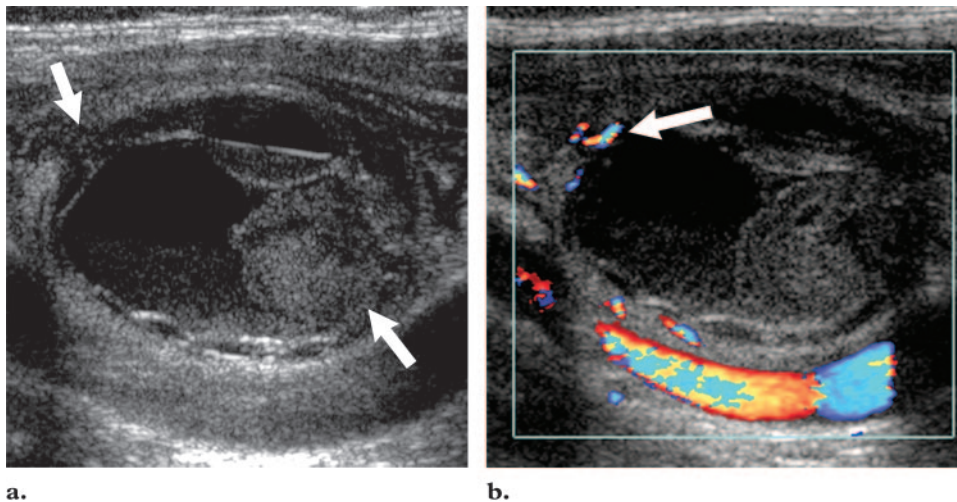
Rare cystic papillary thyroid carcinoma in a 55-year-old woman. (a) Transverse sonogram of the right lobe of the thyroid shows a complex cystic lesion with thick walls and solid components (arrows). (b) Color Doppler sonogram shows vascularity in a small part of the lesion margin (arrow). (c) Axial contrast-enhanced CT image shows the tumor (arrows) but does not clearly depict its complexity.
